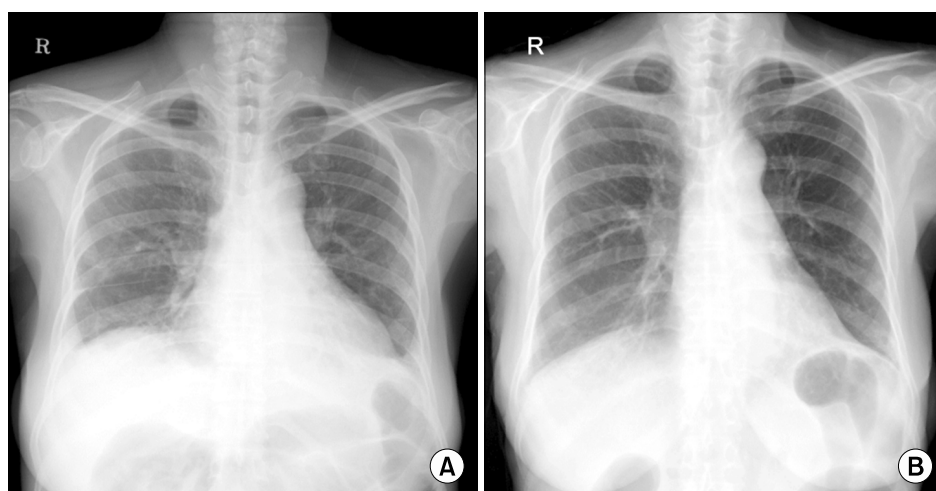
No significant change in interstitial lung disease during the treatment. (A) Chest radiography at diagnosis. (B) Chest radiography 6 years later.
